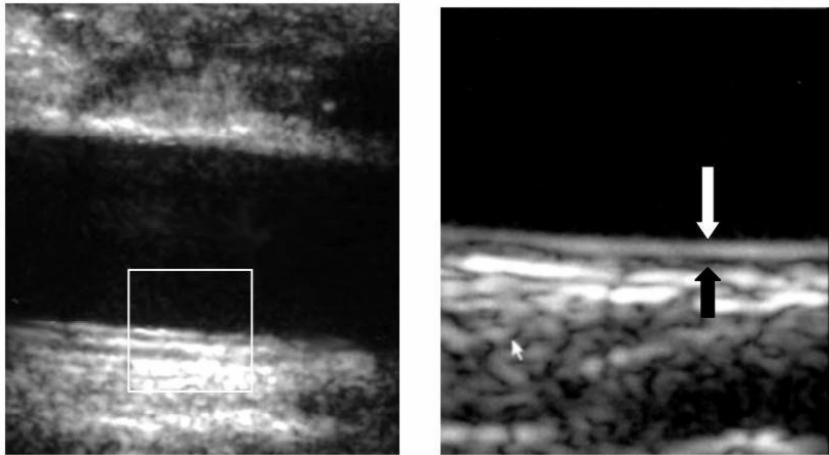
The far wall of the distal abdominal aorta was scanned (on the left), and the intima-media complex was measured from the far wall images, which were magnified using a resolution box function (inset on the left; on the right). The ultrasound visualizes the lumen-intima interface (white arrow) and the media-adventitia interface (black arrow), and the distance between these interfaces is termed intima-media thickness (IMT).
